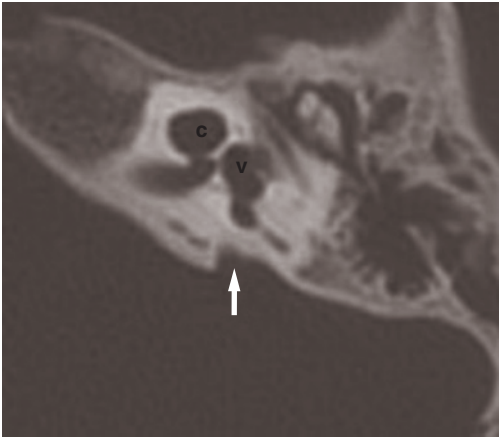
Axial CT scan. ‘Incomplete partition type II’: cystic apex of the cochlea (c), minimal vestibular dilation (v), enlargement of the vestibular aqueduct (arrow).
